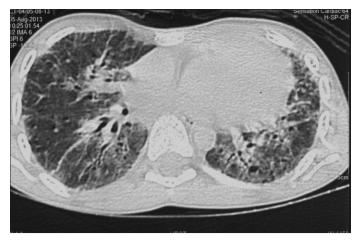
Chest computed tomography scan showing diffuse groundglass opacities
